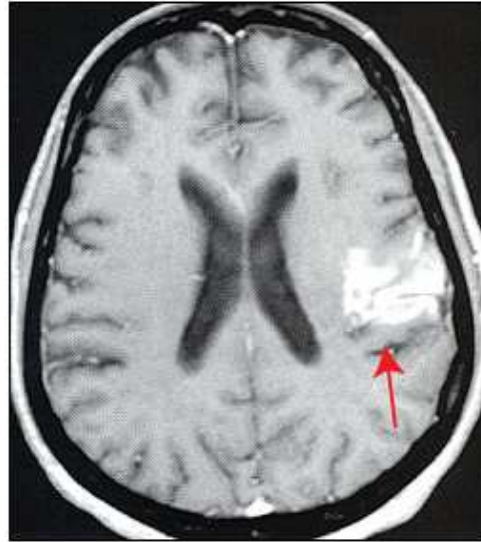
Structural magnetic resonance image of a ischemic stroke (arrow), located on right tempo-parietal area.
